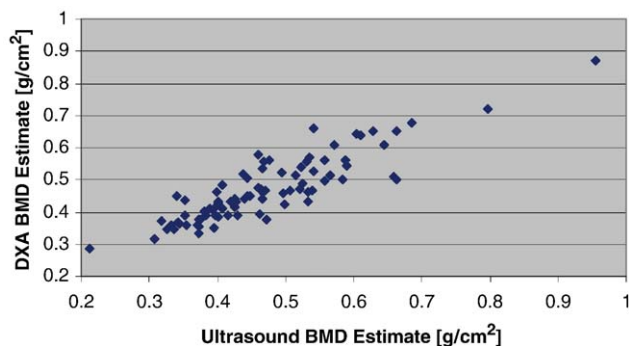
Comparison of ultrasound BMD estimate with DXA BMD estimate.
